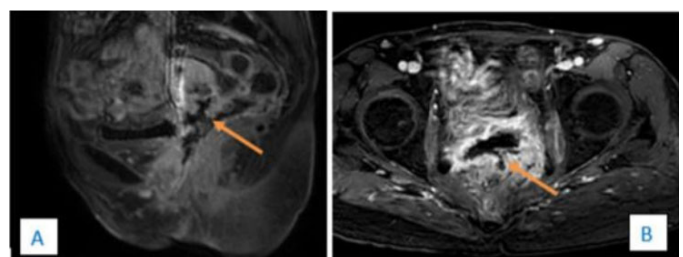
Pelvic MRI in FatSat T1-weighted sequence with gadolinium injection in sagittal (A) and axial (B) sections, in the same patient, showing enhancement of the mucosa along the fistulous path.
